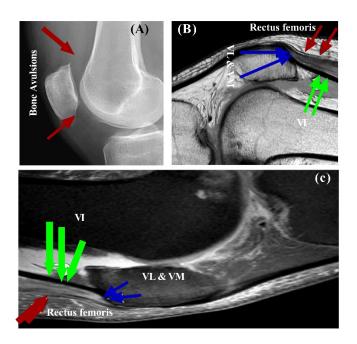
A case study of a conservative treatment of a 35-year-old male athlete with QT tear and signs of bone avulsion in section A, while section B shows A sagittal medial-weighted MR image and section C shows a sagittal MR image without fat suppression. The rectus femoris (red
